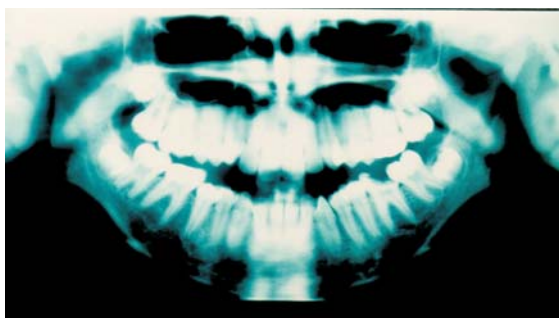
Panoramic radiograph showing the status of first permanent molars and the position of third molars in Case A.
